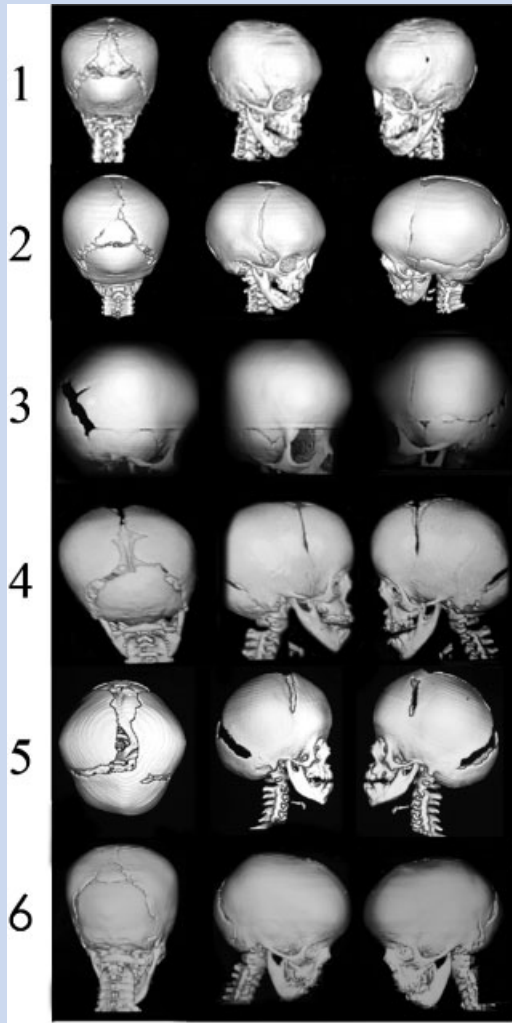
Three-dimensional cranial computed tomography scans of the patients showing wide lambdoidal sutures and coronal synostosis.
